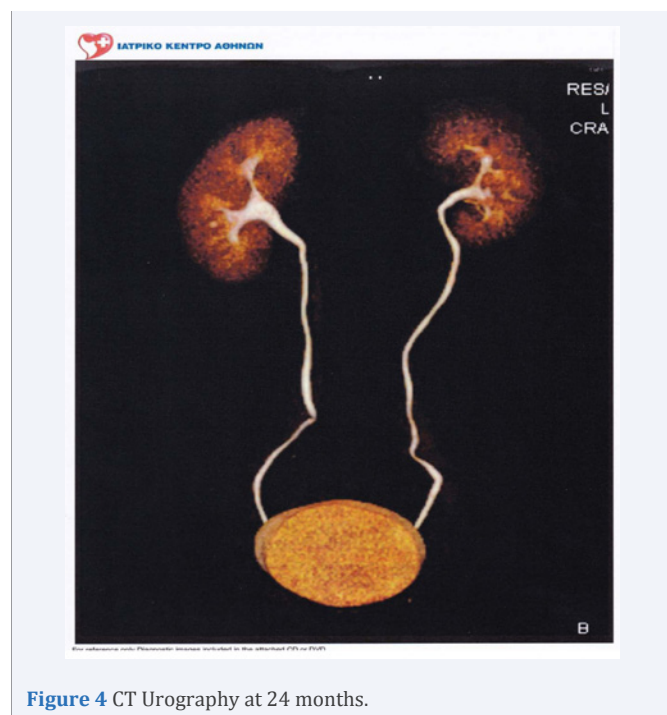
CT Urography at 24 months.
